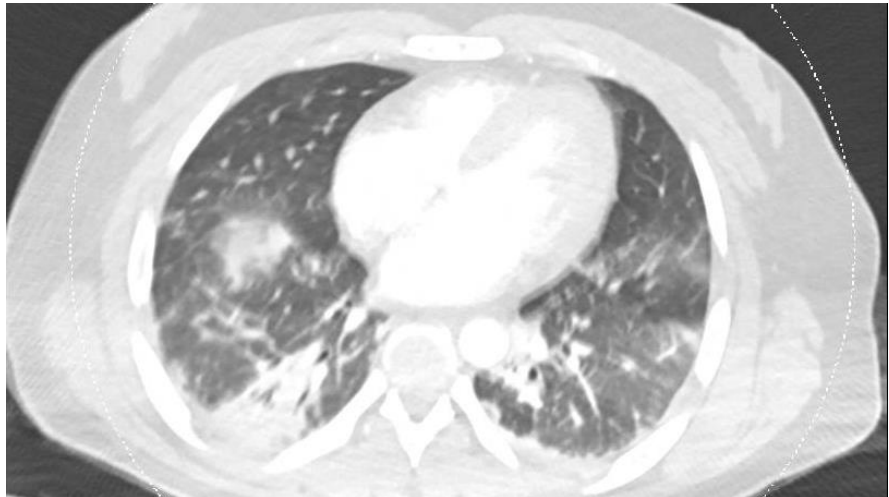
Chest computed tomography during ICU admission.
